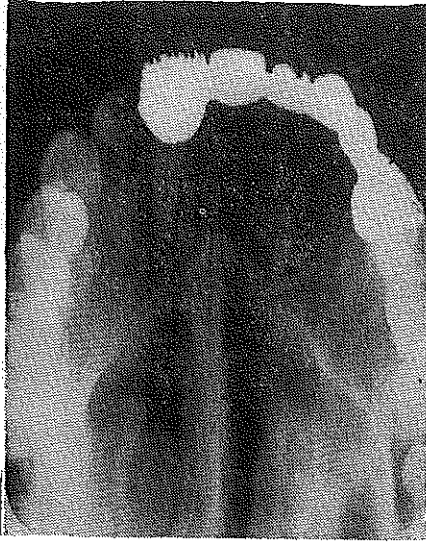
Radiograph showing a large radiolucent lesion below an unerupted maxillary lateral.
